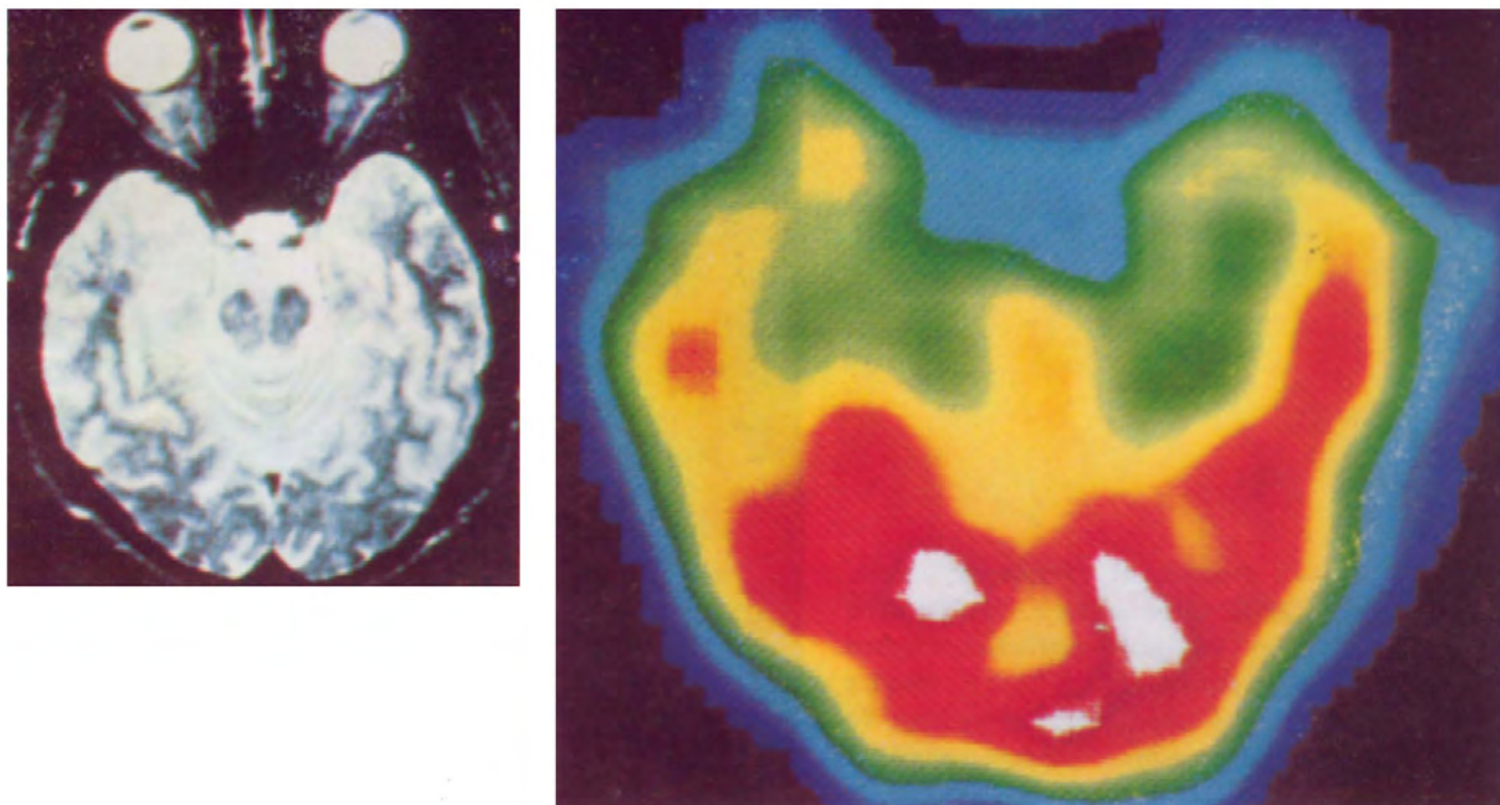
Right temporal lobe hypoperfusion in a patient with a normal MRI. Normal transverse MRI slice (left) and abnormal interictal SPECT study (right).
